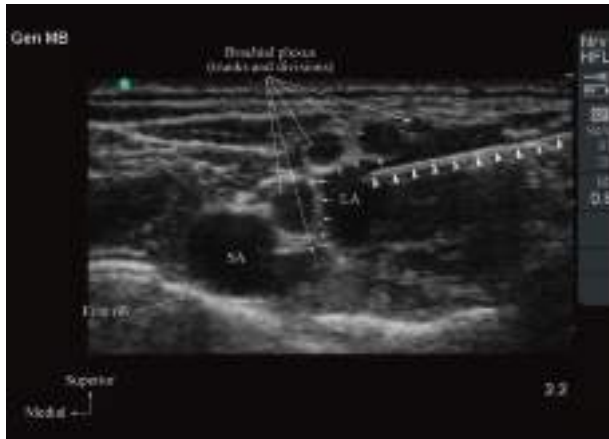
Transverse sonogram of the supraclavicular fossa showing extrafascial injection of LA posterolateral to the trunks and divisions of the brachial plexus. Note the position of the needle (white arrow heads) tip and how the nerves have been pushed away (medially) by the LA.
